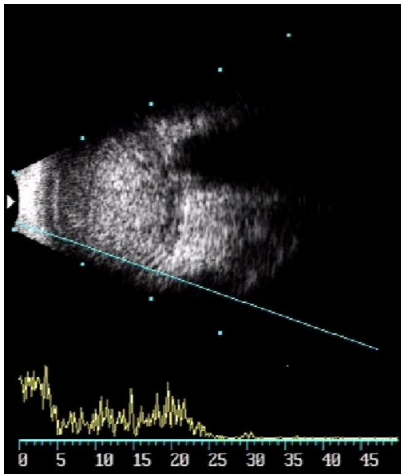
A and B scan ultrasound of endophthalmitis
